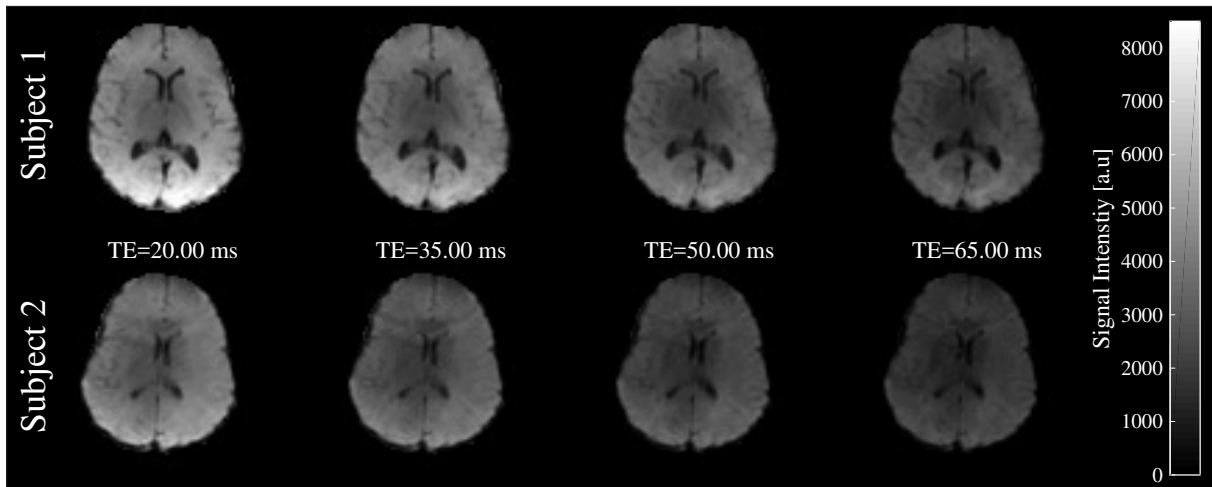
FLAIR EPI images for both subjects at different echo times.
